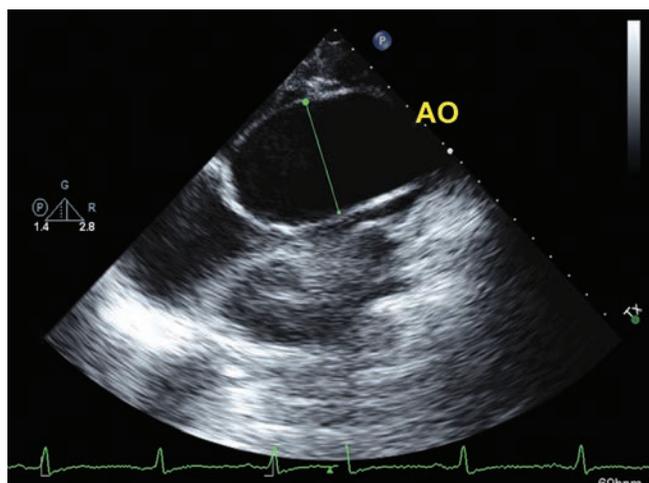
Ascending aorta is examined from the right parasternal approach.
